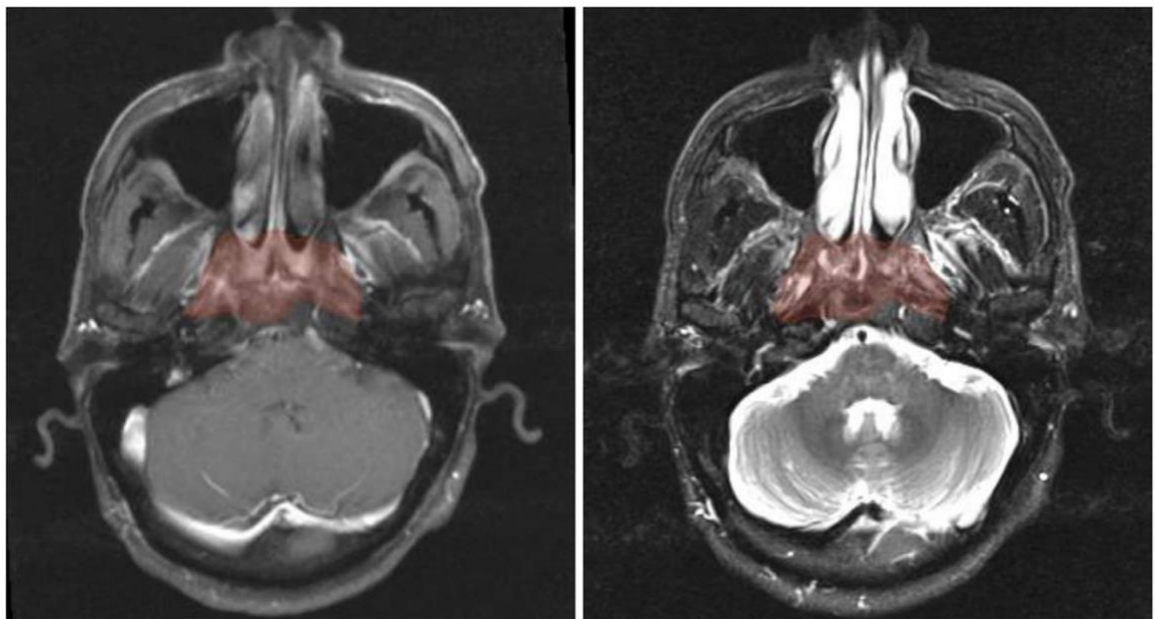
Axial pre-treatment morphological MR images of a 44-year-old man with undifferentiated carcinoma of NPC (T3N2M0). Features of radiomics were extracted from the primary tumor area - GTVnp (red overlay). From left to right: CET1-w and T2-w MR image, respectively.
